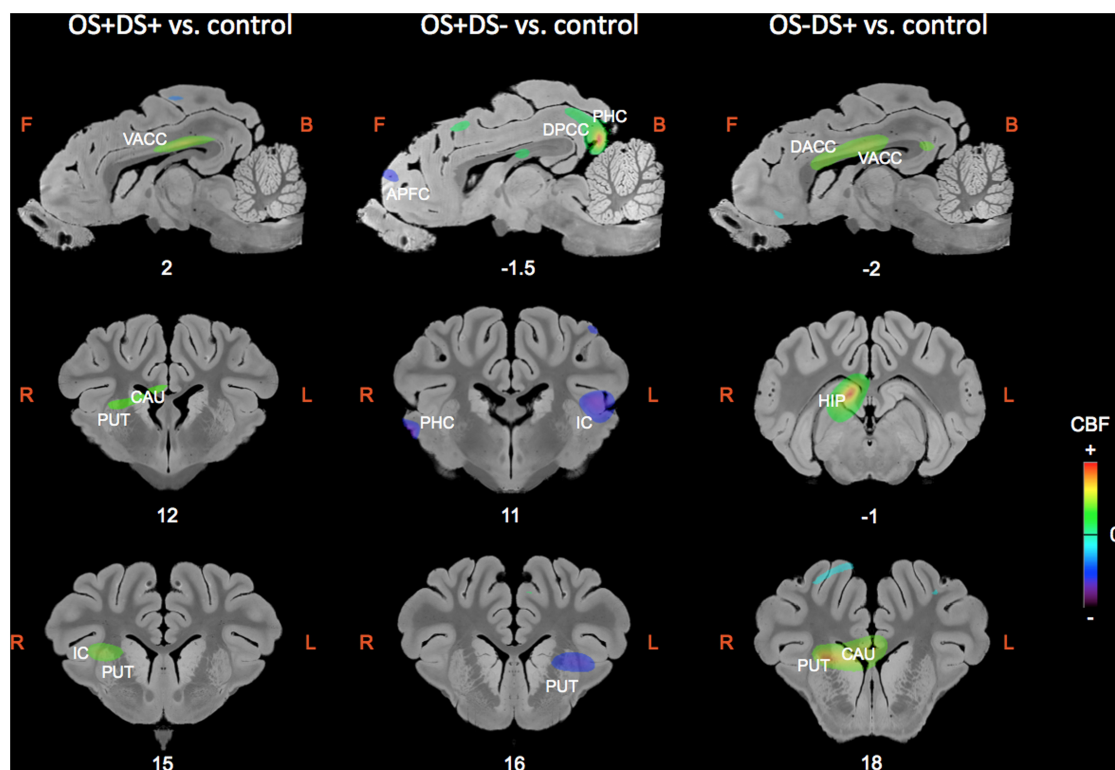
Sagittal and coronal MRI sections showing clusters of differential cerebral blood flow identified during the small volume correction (SVC) analyses in different regions of interest chosen upon *a priori* hypotheses for the three following contrasts: OS+DS+ (oral and duodenal sucrose stimulation) vs. control, OS+DS- (oral sucrose stimulation) vs. control, and OS-DS+ (duodenal sucrose stimulation) vs. control. The x or y coordinates in the CA-CP (commissura anterior-commissura posterior) plane are
